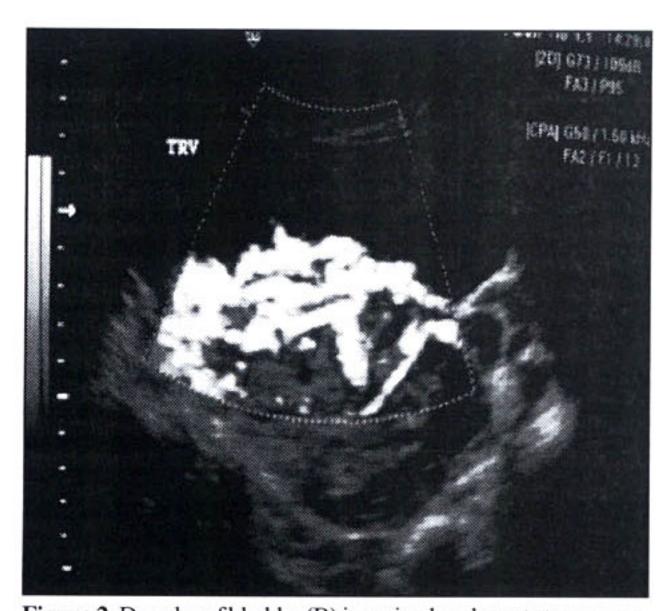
Doppler of bladder (B) invasion by placenta transverse.
